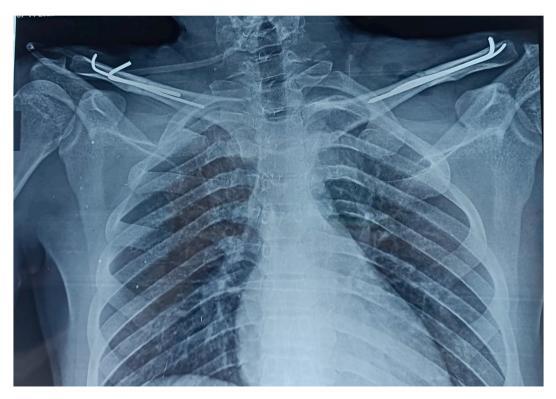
Postoperative X-rays after intramedullary fixation with Kirshner wires.
